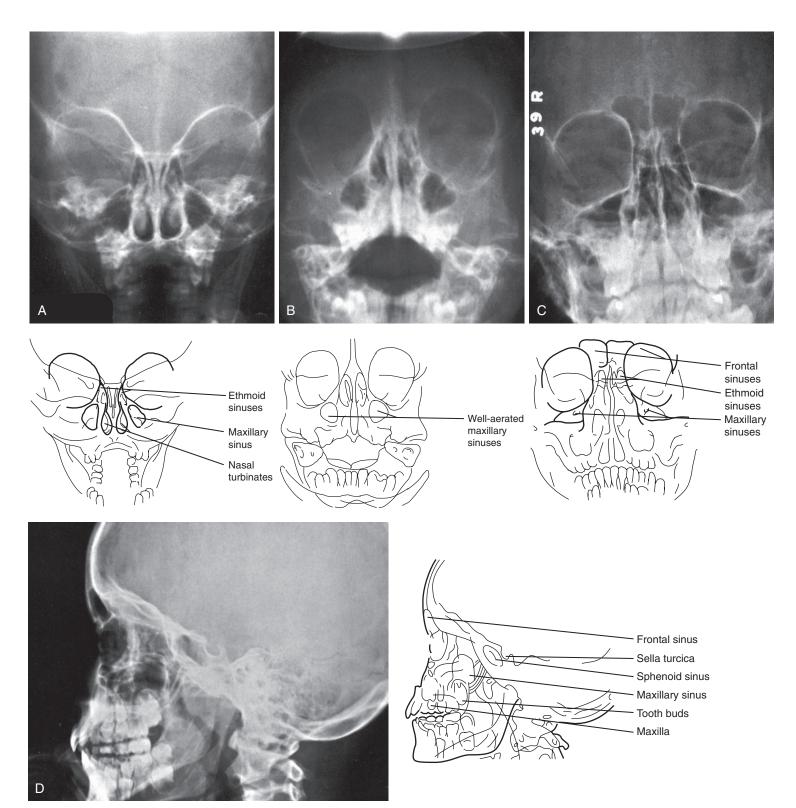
Normal radiography of the sinuses. Radiography is currently the most helpful noninvasive tool for evaluating the paranasal sinuses. Interpretation requires appreciation of the normal pattern of development and the findings in health and with disease. A, Anteroposterior, or Caldwell, view shows clear ethmoid sinuses in an 18-month-old child. The bony margins are sharp, and the sinus cavities are dark. B, The Waters view of the same child shows normal maxillary sinuses with sharply defined bony margins. The cavities appear black. C, After age 6 or 7, the Caldwell view is taken posteroanteriorly. In this 8-year-old boy, the bony margins of both the ethmoid and frontal sinuses are sharply defined. Because the calvarium is superimposed, it can be difficult to appreciate frontal sinus clouding on this view alone, particularly with bilateral disease. Therefore evaluation of the frontal sinuses requires close scrutiny of both Caldwell and lateral views. D, Lateral view of an 8-year-old child shows pneumatization of the frontal sinuses. Note that the roots of the maxillary teeth are embedded in the floor of the maxillary sinus. Note that plain sinus radiographs are quite inaccurate when compared with sinus CT for the diagnosis of sinusitis.
